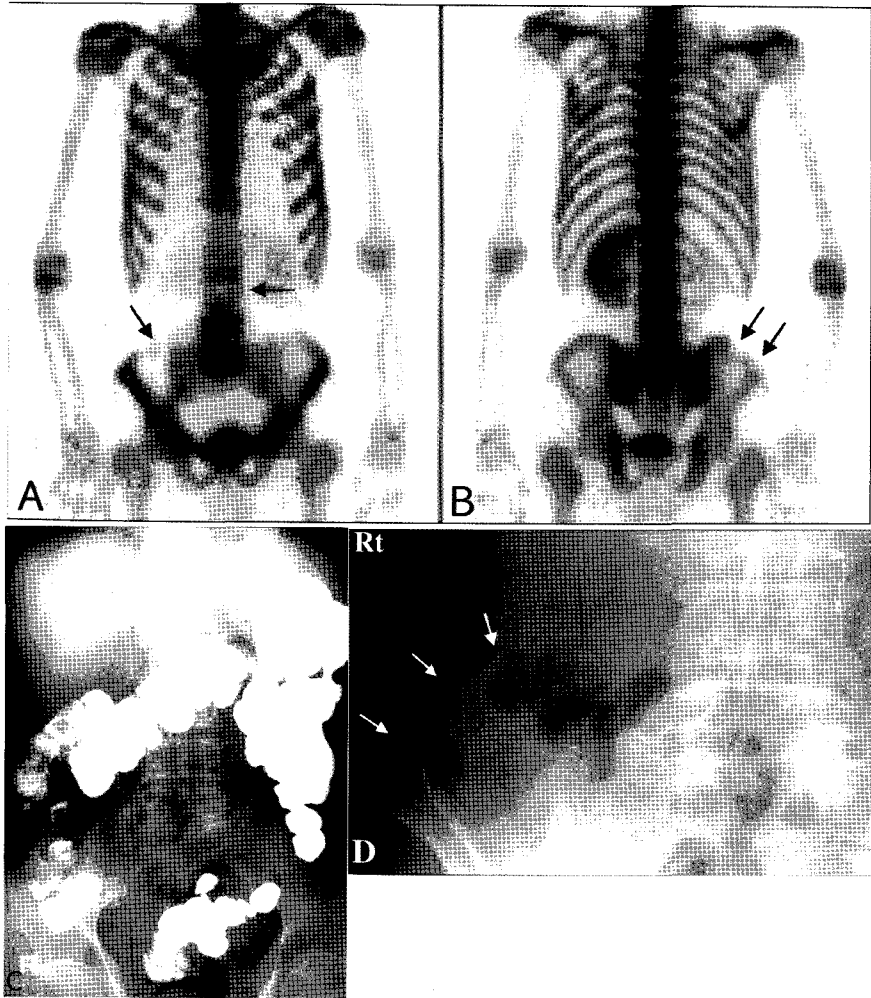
A 61-year-old man with squamous cell carcinoma in the pharynx underwent Tc-99m MDP bone scintigraphy for the evaluation of bony metastases. Six years prior to the current admission, the patient had a subtotal gastrectomy for gastric cancer. Nine years ago, the patient had a traffic accident. (A) Anterior image of bone scintigraphy demonstrated photon defects (arrows) in the L3 vertebral body and the right iliac crest with decreased right renal activity. (B) Posterior image demonstrated photon defects (arrows) only along the right iliac crest. The photon defects might cause a false impression of cold metastases. However, if we carefully examined, the curvilinear or tubular shaped photon-deficient region could be recognized in the upper and right abdomen. Two days before bone scintigraphy, the patient had a barium enema. (C) Plain radiography of the abdomen demonstrated residual barium in the ascending colon, hepatic flexure of the colon, transverse colon causing artifactual defects. Seven days later, (D) follow-up plain radiography of the abdomen demonstrated bony defects (arrows) along the right iliac crest due to previous traffic accident, corresponding to photon defects along the right iliac crest revealed in the posterior image. Decreased right renal activity correlated with stenosis of the right renal artery on MRI of the abdomen.
